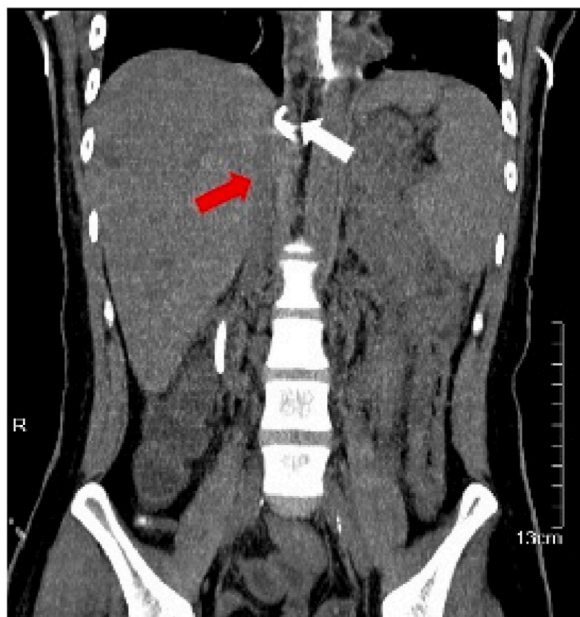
Non-contrast abdominal CT scan showed no cystic lesion or compression of IVC anymore. White arrow: the tube retained in the lesion; Red arrow: the normal IVC without compression. Abbreviation: IVC: inferior vena cava.
